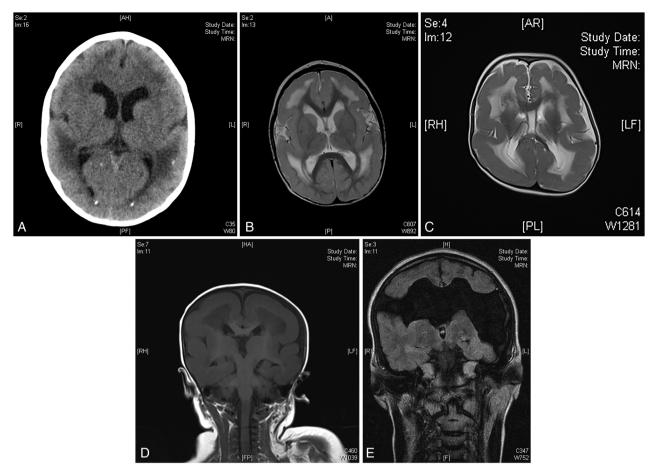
(A) CT scan of head showing intracranial calcification associated with early cytomegalovirus infection. (B) MR scan of brain (T2-weighted) showing extensive polymicrogyria typical of a congenital cytomegalovirus infection. (C) MR scan of brain (T2-weighted) showing lissencephaly, a cerebral maldevelopment often associated with the *LIS1* gene mutation. (D) MR scan of brain (T1-weighted) showing lissencephaly. (E) MR scan of brain (T1-weighted) showing bilateral open-lipped schizencephaly, which can be associated with *COL4a1* genetic mutation predisposing to early infarcts.
